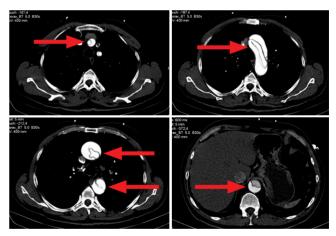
The manifestation of the patient that is compliant with aortic arch dissection in his dynamic thorax-abdomen CT
